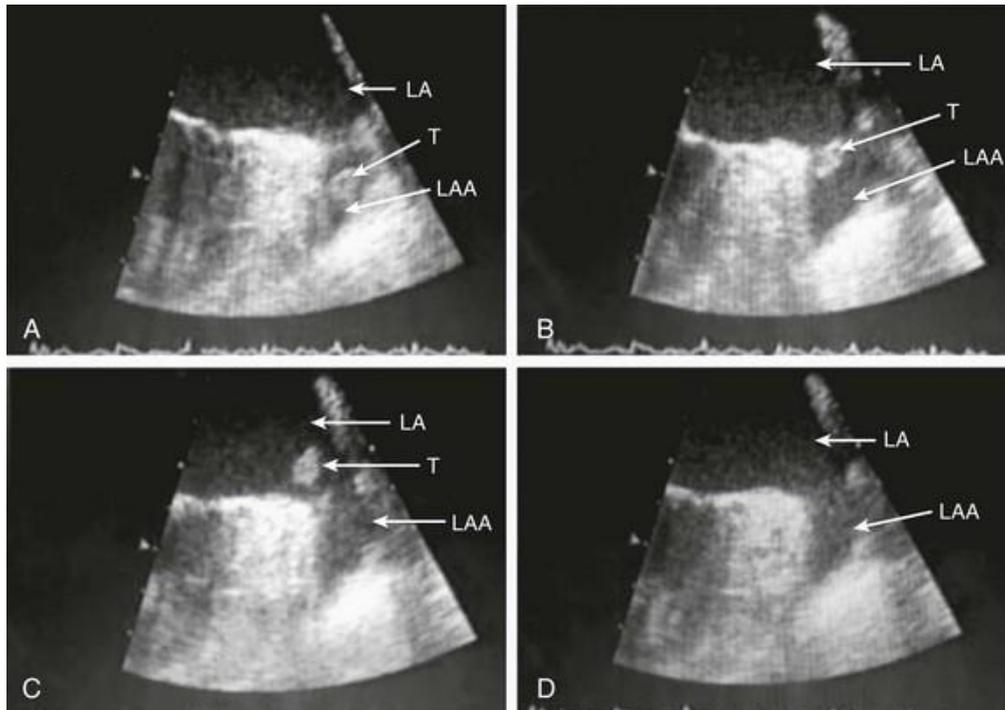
A, Echocardiographic assessment documenting thrombus (T) in the left atrial appendage (LAA). During the Echo, the thrombus is seen to migrate from the LAA out into the left atrium (LA) and then embolize from the LA (B-D).^[15]
